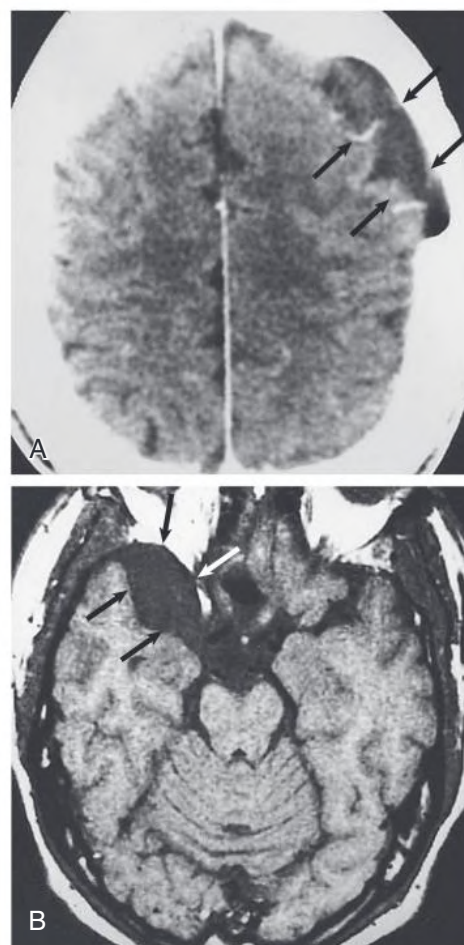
Extracranial Manifestations of Autosomal Dominant Polycystic Kidney Disease (ADPKD). Computed tomography (A) and magnetic resonance imaging (B) scans demonstrate cysts in the arachnoid membrane (*arrows*) in ADPKD.
